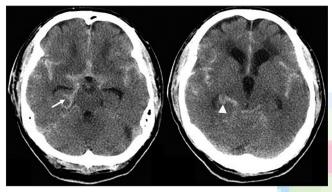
Brain computed tomography showing typical subarachnoid hemorrhage and aneurysm rupture. There was asymmetrically more subarachnoid hemorrhage at the right ambient cistern (arrow), which was not believed to be meaningful until the patient began re-bleeding. An intracerebral hemorrhage was found in the right hippocampus (arrowhead), without intraventricular hemorrhage
